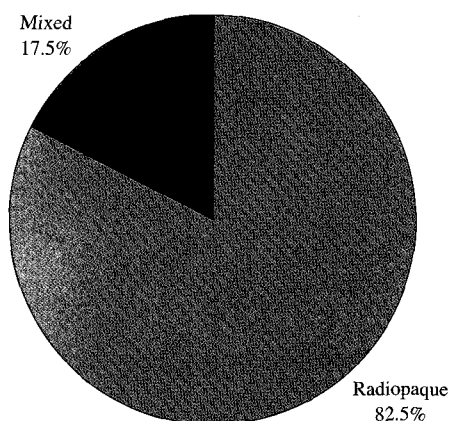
Radiographic density of 63 COD lesions.
